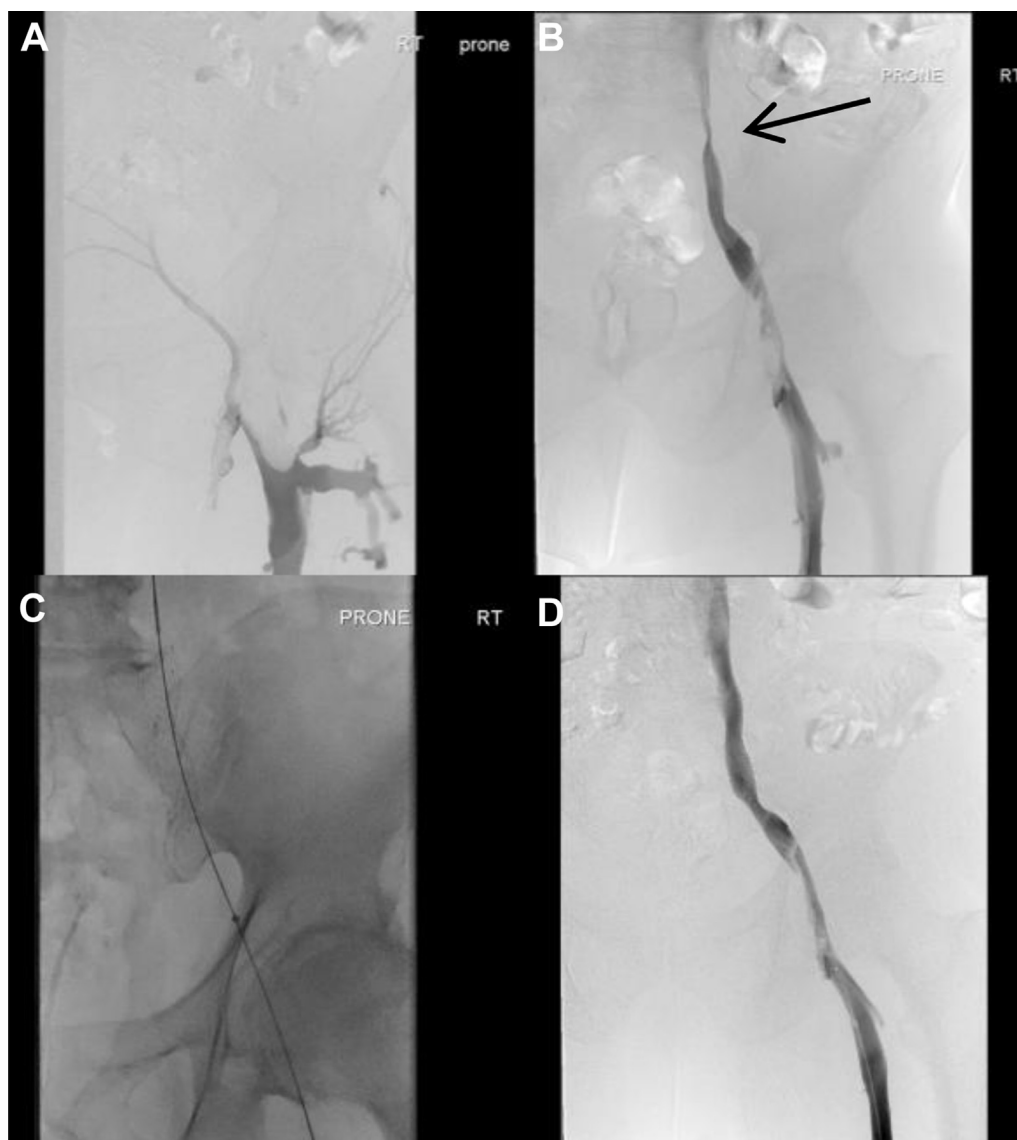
Venography images demonstrating diagnosis and management of the deep vein thrombosis (DVT) and vascular compression. A, There is a meniscus sign and expansion of the vein in the right proximal femoral vein/distal external iliac vein in keeping with thrombus. B, After 1 day of catheter-directed thrombolysis (CDT), thrombus remains in the right proximal femoral vein/distal external iliac vein. Note that in the proximal external iliac vein, there is a stenosis compatible with the area of vascular compression identified on computed tomography (CT; *arrow*). C, Insertion of a 16-mm \times 6-cm self-expanding Zilver Vena venous stent in the region of the venous stenosis. D, After 2 days of catheter-directed thrombolysis in addition to mechanical thrombectomy using the AngioJet Solent Omni catheter, there is a significant reduction in the volume of clot in the right proximal femoral vein/distal external iliac vein with small burden of residual clot. There is also improved flow in the deep venous system to the central veins.
